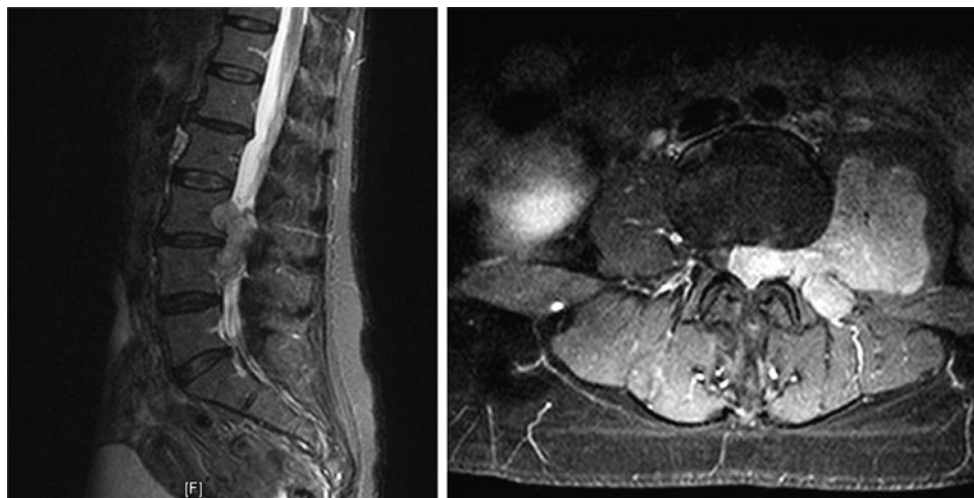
T2-weighted, contrast-enhanced MR images showing a hemangiopericytoma of the lumbar spine. The tumor displaces the dura and the nerves and grew into the extraspinal space and into the paraspinal tissue and muscles
